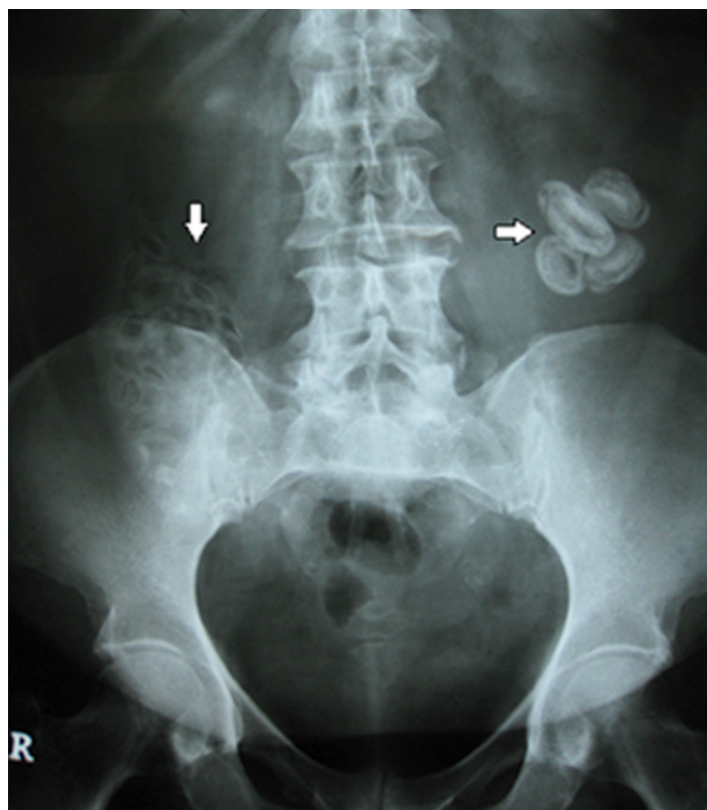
Radiography of the abdomen revealing radio-opaque shadows (arrowheads).
